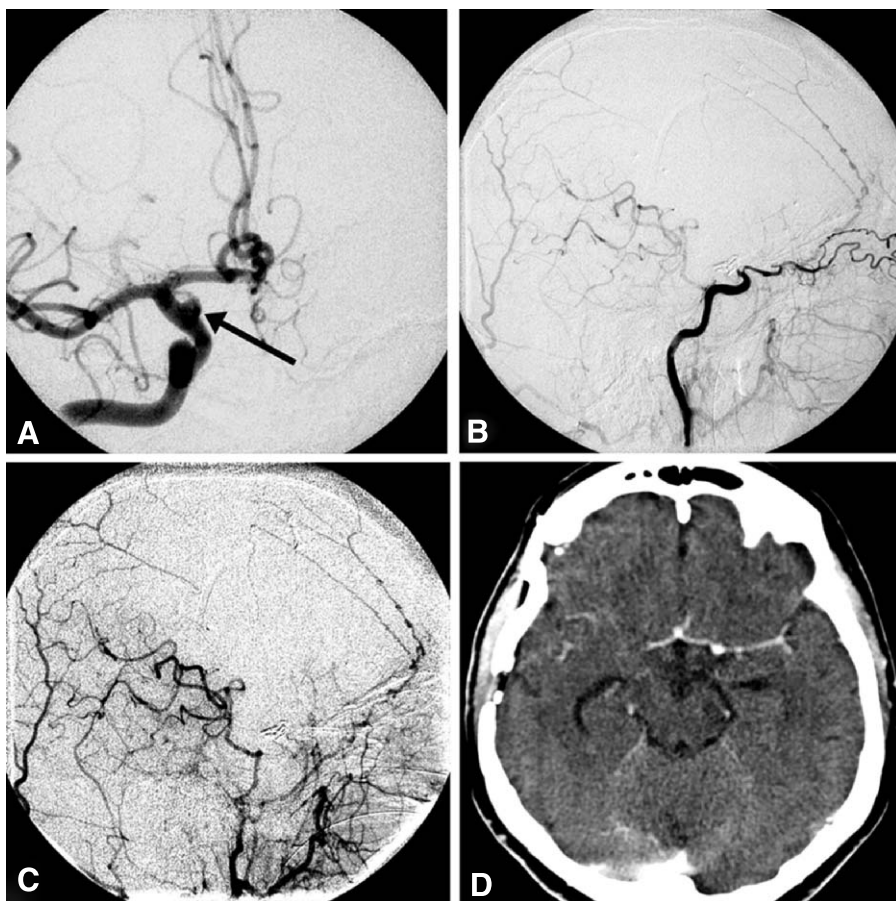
Case 1* Angiography before surgery (A) showing a blister-like aneurysm of the right ICA (arrow). Angiography after surgery showing a functioning bypass (C) and the trapped carotid artery distal to the origin of the ophthalmic artery (B). CT after surgery (D) with no signs of ischemia
